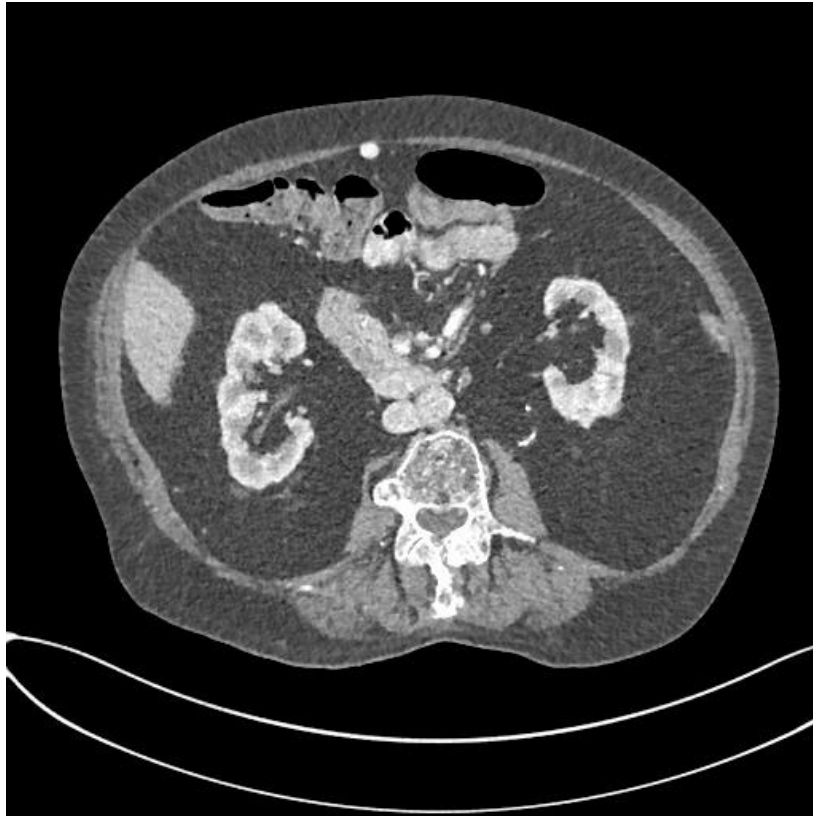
Axial CT slice demonstrating a diffuse retroperitoneal fatty mass with medial displacement of the kidneys bilaterally.
